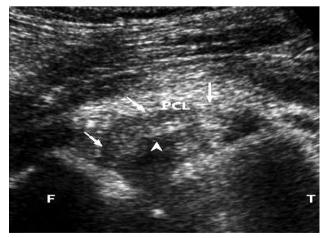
Ultrasound image showing contused thickened PCL (arrows) with tear (arrowhead).
